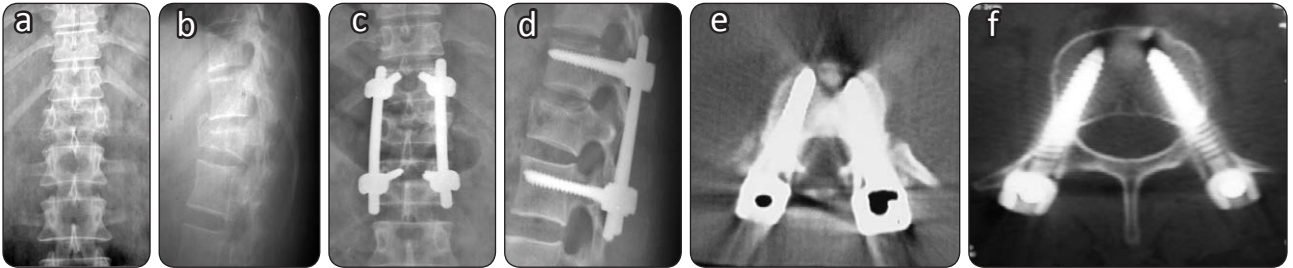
28 years old male patient with fracture L1. The images demonstrate the preoperative plain X-ray anteroposterior (a) and lateral (b) views, plain X-ray postoperative anteroposterior (c) and lateral (d) views, CT scan postoperative showing upper level screws (e) and lower level screws (f).
